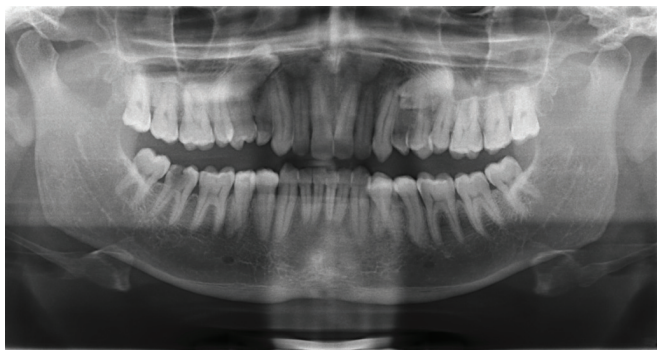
The panoramic radiograph confirmed the presence of 2 impacted supernumerary teeth located bilaterally above the apices of maxillary premolars lying obliquely
